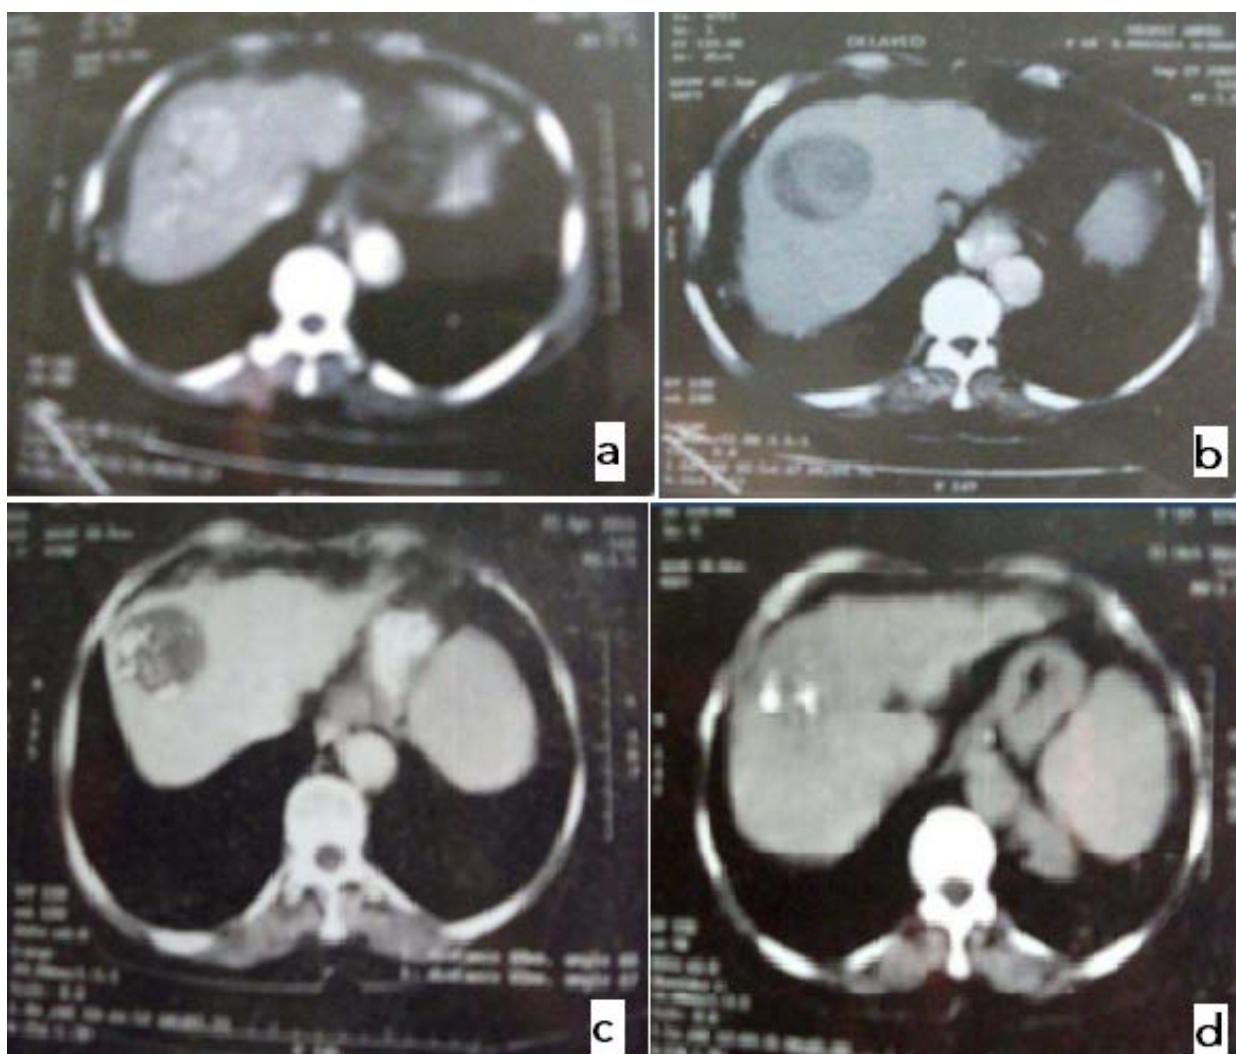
(a, b) CT study showing HCC before treatment. (c) CT study showing complete ablation 3 months after combined ethanol and mitoxantrone (no uptake in the arterial phase) with lipidol inside. (d) CT study showing complete ablation 6 months after combined ethanol and mitoxantrone (no uptake in the arterial phase) with lipidol inside.
